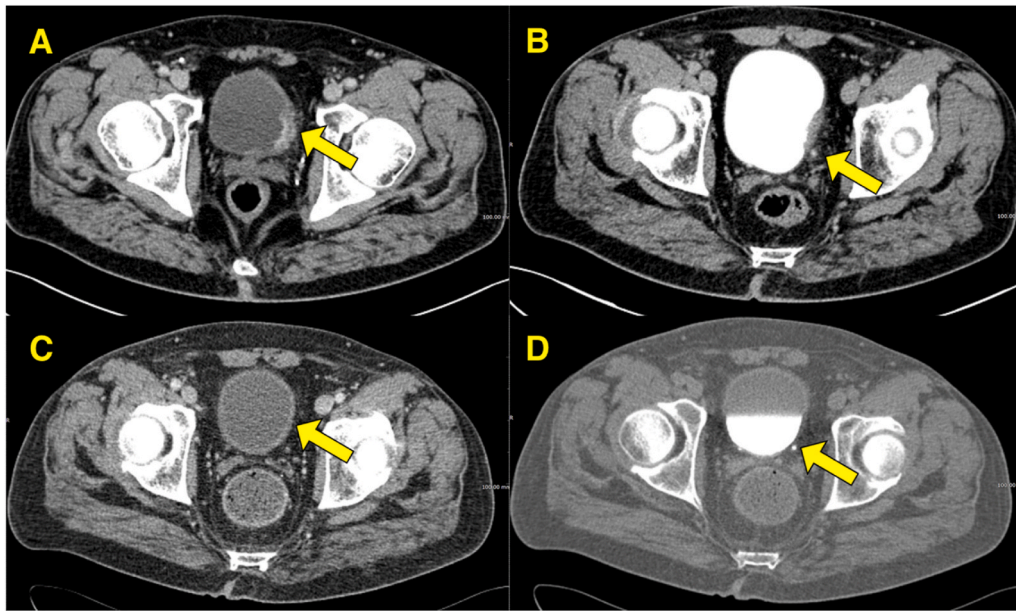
Comparative CT with contrast images of the bladder neof ormation, before and after neoadjuvant chemotherapy treatment; A. Image before neoadjuvant treatment; C. Image after neoadjuvant treatment: we observed a total disappearance of the parietal lesion; B. Image before neoadjuvant treatment; D. Image after neoadjuvant treatment: the filling defect is no more detectable.
